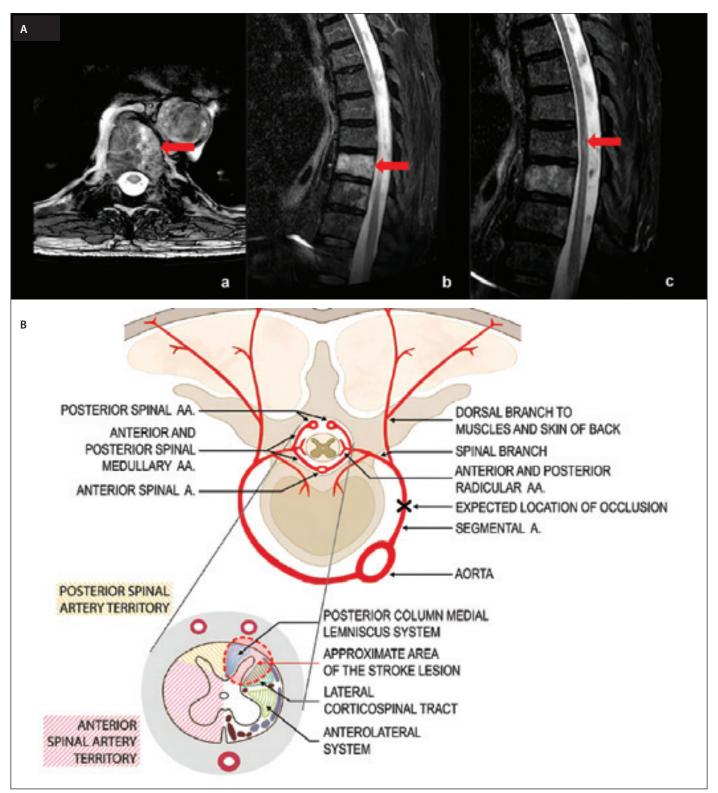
(A) MRI – newly observed pathological signal (red arrow) in the left half of the vertebral body at the level of T9, indicating changes related to a bone infarct: (a) balanced turbo field-echo (B_TFE) sequence in the transverse plane, (b) STIR sequence in the sagittal plane. Discrete spinal cord inhomogeneities are seen on the STIR sequence at the T8 vertebra level (c). (B) Arterial blood supply to the spinal cord and thoracic vertebrae.
